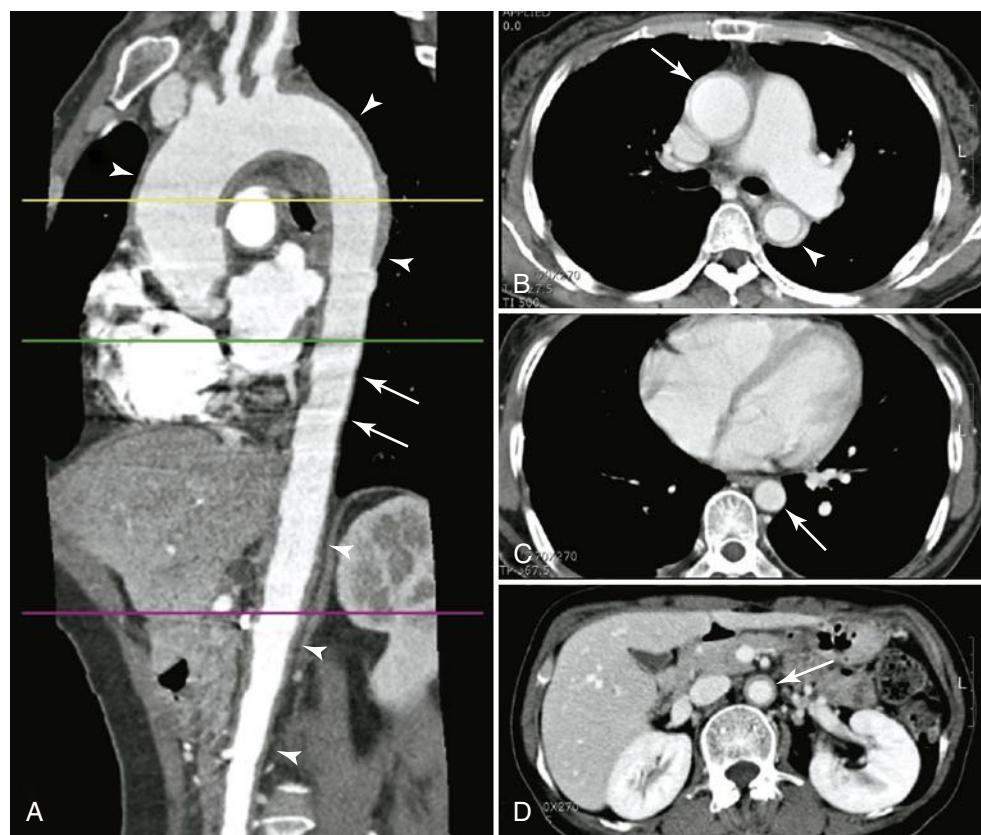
Takayasu Arteritis Involving the Aorta with a Skipped Segment in a 50-Year-Old Woman. (A) Multiplanar reformation image shows wall thickening (arrowheads) of ascending thoracic aorta, aortic arch, proximal descending thoracic aorta, and abdominal aorta. No wall thickening of distal descending thoracic aorta is noted. Motion artifact (pulsation artifact) was not observed in the thickened segment, such as the aortic arch and abdominal aorta, because of stiffness of the involved aorta but was observed in the distal descending thoracic aorta (arrows) owing to pulsation of the noninvolved segment. (B) Computed tomography (CT) scan at the proximal descending thoracic aorta shows diffuse wall thickening and inner low-attenuation ring of ascending (arrow) and descending thoracic aorta (arrowhead). (C) CT scan at the distal descending thoracic aorta (arrow) shows no wall thickening of aorta. (D) CT scan at the abdominal aorta shows diffuse wall thickening and inner low-attenuation ring of abdominal aorta (arrow). (From Chung JW, et al. Patterns of aortic involvement in Takayasu arteritis and its clinical implications: evaluation with spiral computed tomography angiography. *J Vasc Surg.* 2007;45:906–914.)
